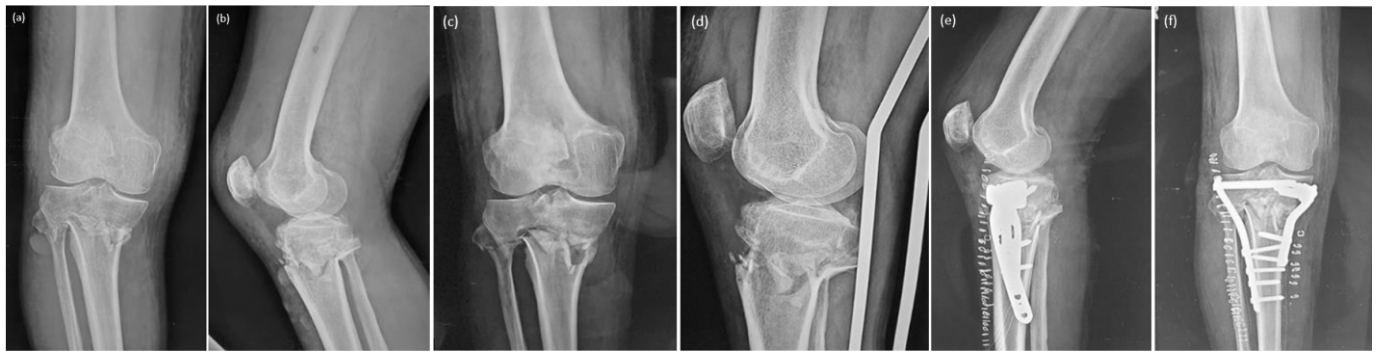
Case 1 Proximal tibia fracture radiographs anteroposterior and lateral views (a, b), with traction (c, d), post operative (e, f)
